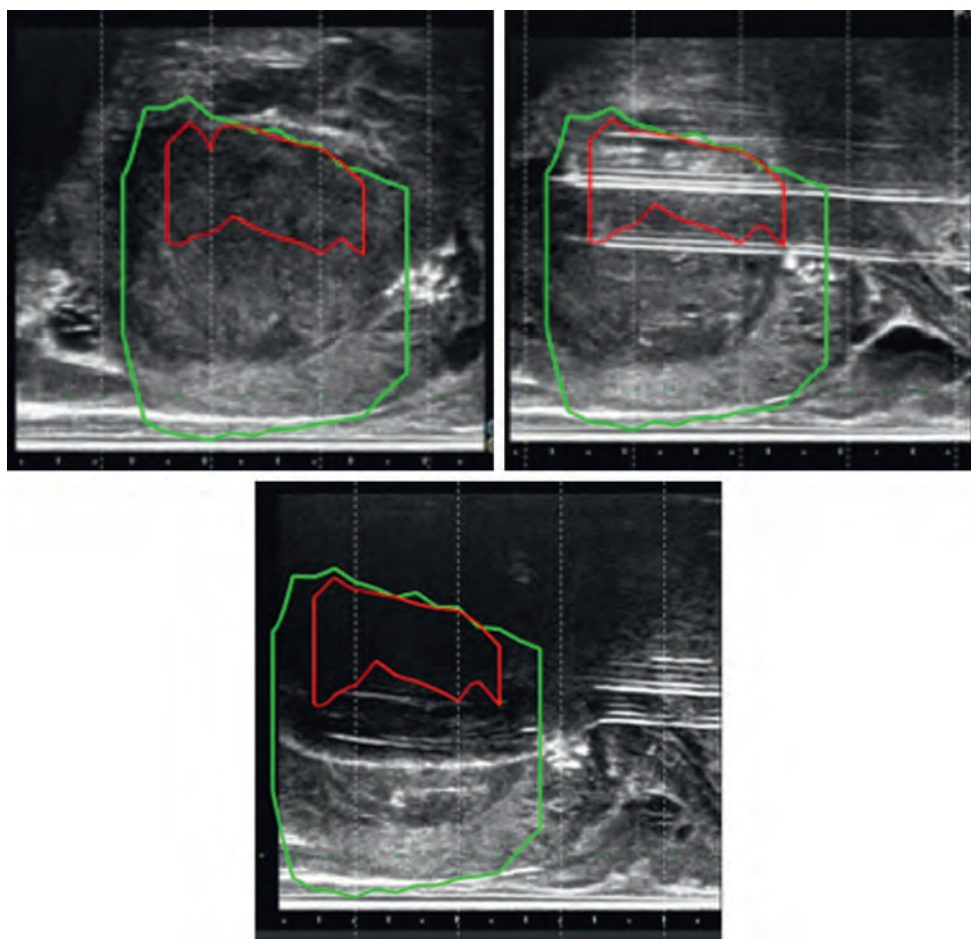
The man from [Figures 117-22](#) and [117-23](#) opted for focal cryotherapy after appropriate counseling. This was guided by image fusion so the needles could be placed accurately into lesion and ensure a margin was incorporated into the treatment. *Red* represents lesion contour from magnetic resonance imaging (MRI); *green* represents prostate contour from MRI.
